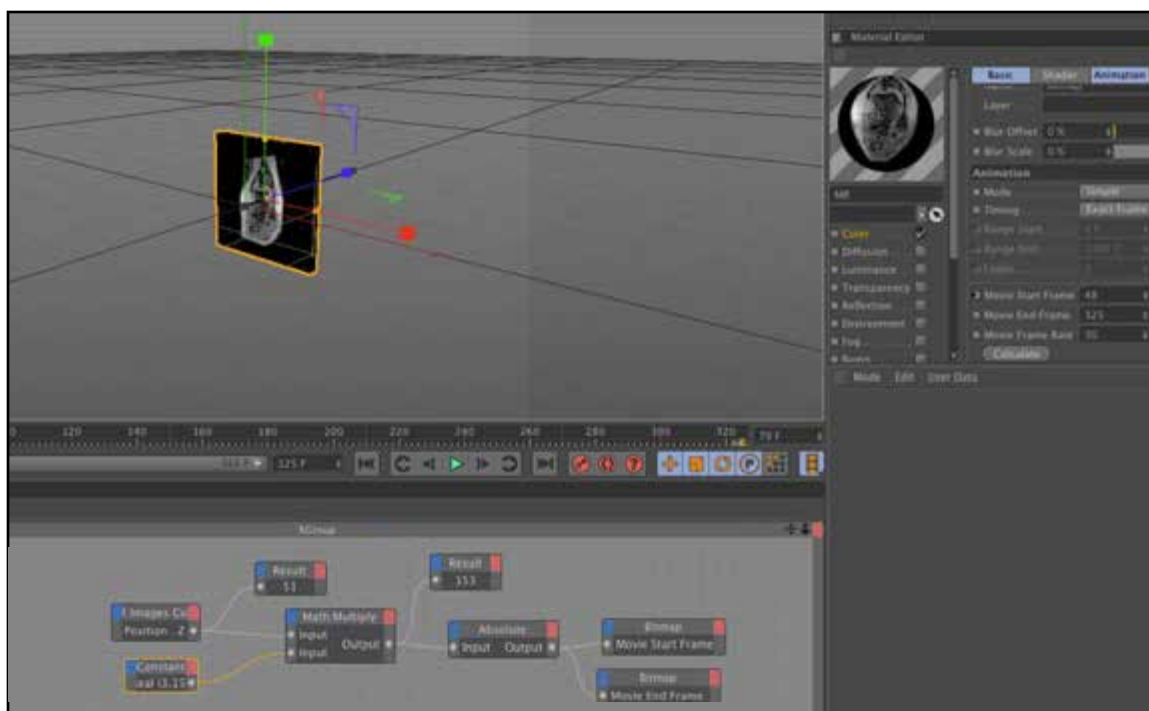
Xpresso setup for MR image slices.
